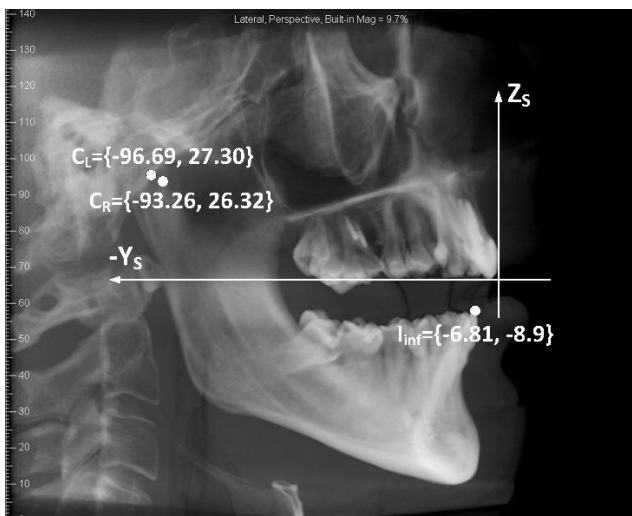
Lateral and frontal X-ray of the patient with coordinates of the points of interest.
